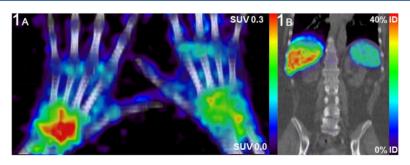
(A) Example of a [1241]I-F8-IL10 PET-CT scan of the hands of RA patient 3 with clinically active disease. (B) [124I]I-F8-IL10 PET scan of RA patient 1 showing clear tracer uptake in liver and spleen. %ID = percentage of the injected dose.
